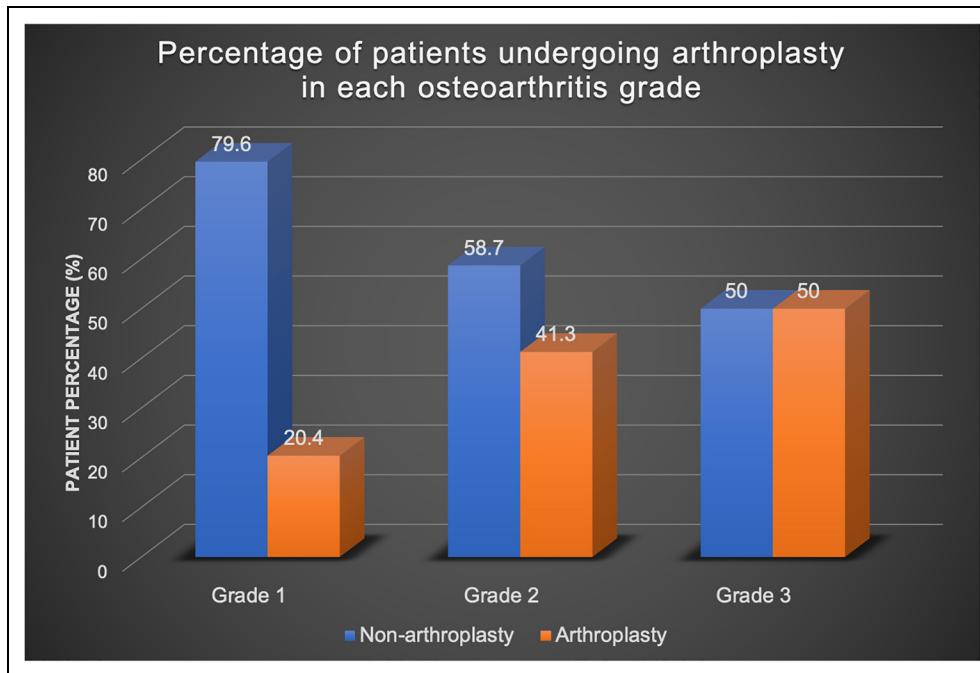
Radiographic severity of osteoarthritis at the time of injection was found to be a significant predictor of undergoing arthroplasty in future. Fifty percent of the shoulders with grade-3 arthritis received arthroplasty, whereas 20% of those with grade-1% and 41% of those with grade-2 arthritis received arthroplasty.
